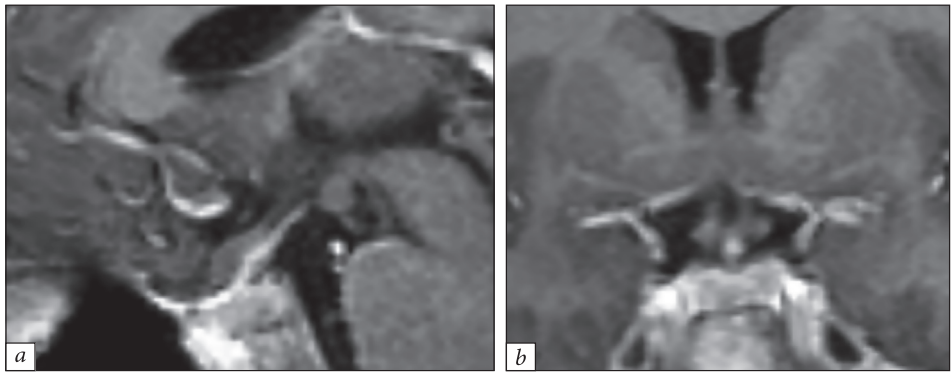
Postoperative MRI: (*a*) sagittal and (*b*) coronal T1-weighted images showing no signs of residual tumor
